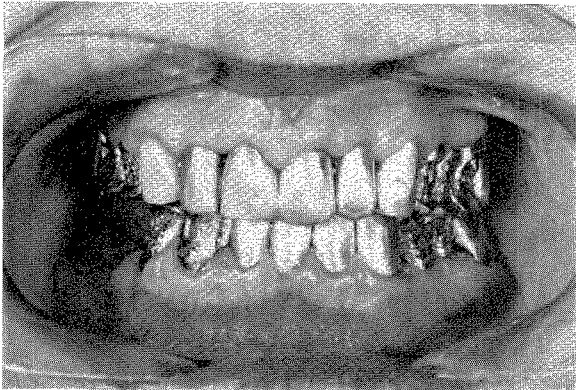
This is the first try-in of the completed posterior castings. Centric occlusion, vertical dimension, cervical fit, etc. will be established. Roentgenograms and new plaster impressions will be taken. Wax records will again be made to check centric relation.
